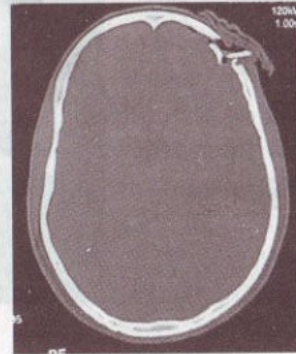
CT scan showing depressed fracture of left frontal bone
